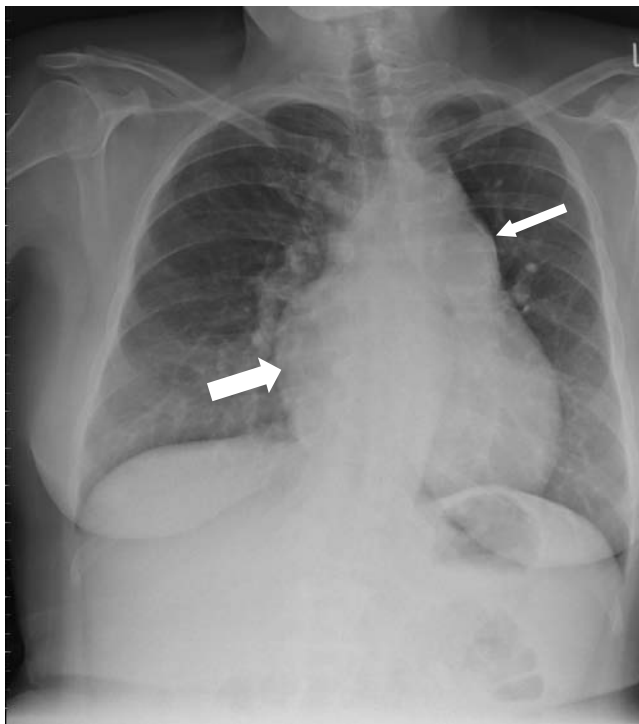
Chest x-ray of our patient shows scoliosis, calcified and dilated pulmonary artery and patient ductus arteriosus (thin arrow), enlarged RA (big arrow), and increased cardiothoracic ratio.
